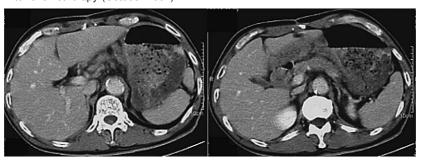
Abdominal CT Arrows present existence of tumor.
